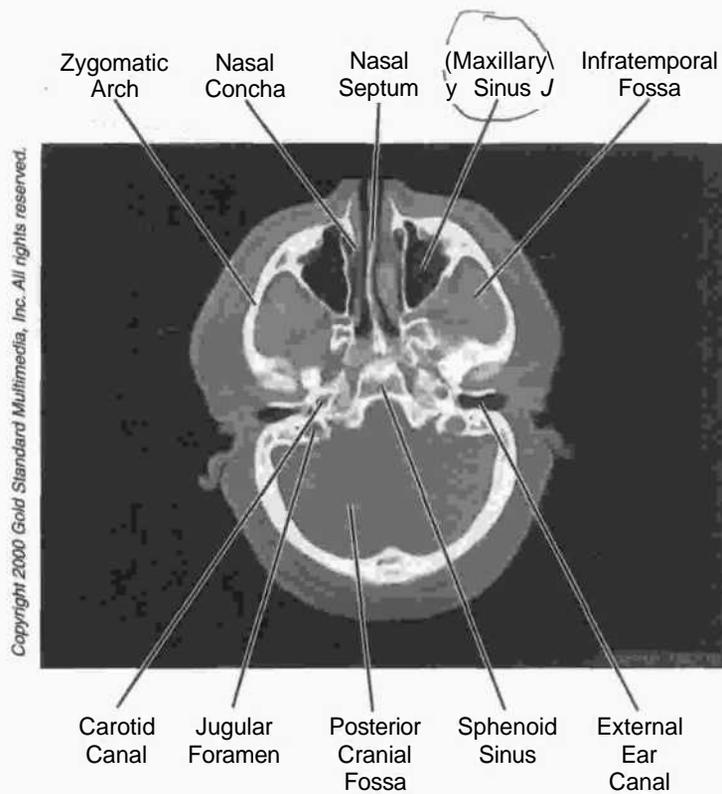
Head and Neck: CT, Skull
